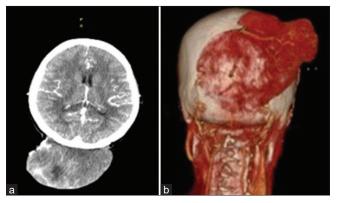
Computed tomography-scan showed (a) Mix density mass (b) 3D Imaging showed received blood supply from both the superficial temporal arteries.
